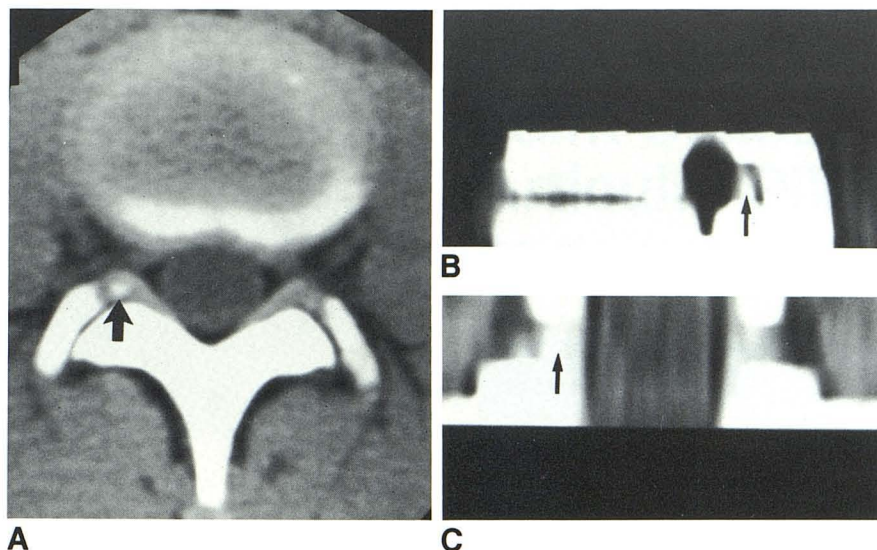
17-year-old woman. A, CT scan. Presumed ossicle (arrow) behind yellow ligament at L2–L3. Ossicle is separated from lateral part of superior articular process of L3. Reformatted sagittal (B) and coronal (C) images. Ossicle (arrows) above superior articular process.
